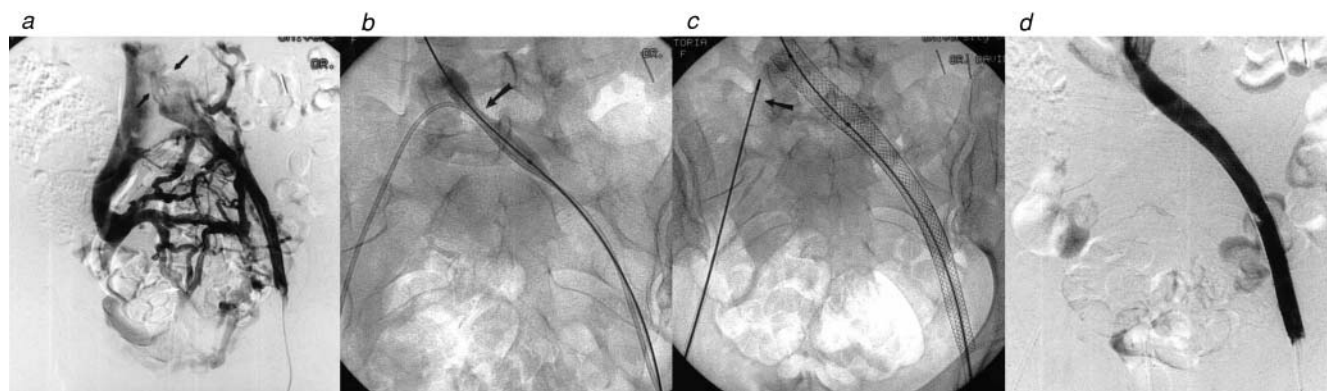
This panel depicts a lower extremity venogram of a patient with May-Thurner syndrome and its subsequent endovascular treatment. (a) Descending venogram demonstrating minimal reflux into the left iliac system and extensive, secondary pelvic collaterals. Arrows indicate the area of stenosis of the left common iliac vein. (b) Balloon venoplasty of the left common iliac vein. The arrow identifies the area of compression on the balloon within the vein. (c) Placement of a stent from the common iliac vein to the external iliac vein. The arrow demonstrates an intravascular ultrasound probe in the right iliac vein. (d) Retrograde venogram after venoplasty and stenting of the left iliac vein demonstrating a patent iliac venous system and resolution of the left-sided pelvic collaterals. Reproduced with permission from Hurst DR et al.¹⁰⁶
